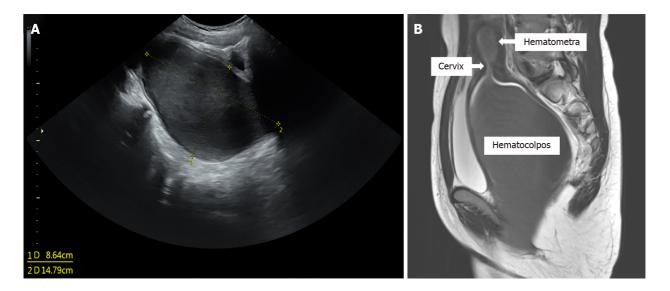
Radiological images. A: Transabdominal ultrasound shows a hypoechoic cystic mass below the bladder (14.79 cm × 8.64 cm); B: Pelvic magnetic resonance imaging shows marked distention of the uterus and vagina with blood clots.
